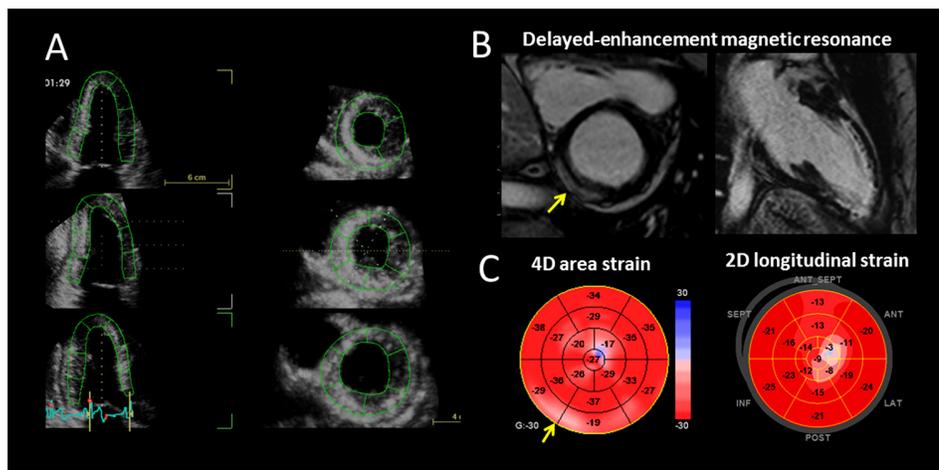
Left ventricular deformation analysis (4D area strain and 2D longitudinal strain) in a 37-year-old patient with no classical risk factors, presenting with signs of anterior myocardial infarction due to an occlusion of the left anterior descending coronary artery. A, Region-of-interest (ROI) for 4D Strain analysis, covering the entire wall thickness in three dimensions and displayed in 3 apical and 3 short-axis views of the left ventricle. B, Contrast-enhanced magnetic resonance imaging showed transmural necrosis in anterior segments and a second region of delayed enhancement (arrow) localized at the basal infero-posterior segments at epicardial level interpreted as focal myocarditis. C, Deformation analysis shows reduced strain in the infarcted antero-apical segments, but only the analysis of area strain (combining longitudinal and circumferential deformation) by 4D Strain has identified regional abnormalities in the infero-posterior basal region of the left ventricle in this case (arrow, left image). In contrast, 2D longitudinal strain by AFI/2D Strain, which mainly reflects subendocardial function, has not identified any abnormality in infero-posterior region, but clearly delineated the infarcted region (right image).
